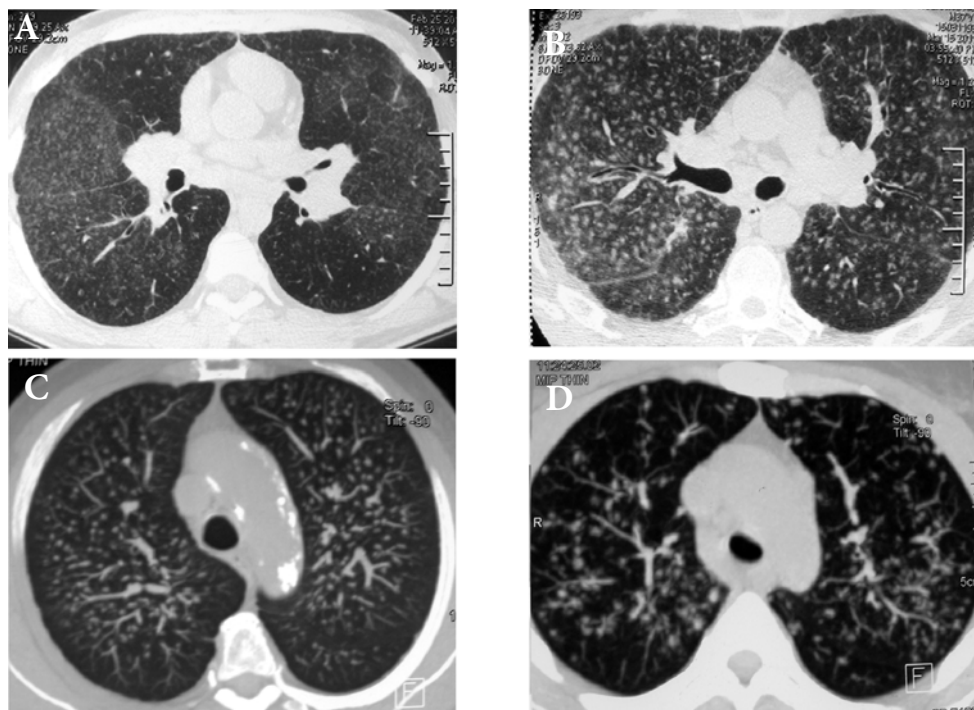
HRCT appearance of pulmonary sarcoidosis. Nodules are the hallmark of sarcoidosis. They are typically distributed in a perilymphatic manner. HRCT can show a large variety of these nodules: from very fine, poorly defined nodules (A, B), accompanied by diffuse ground glass attenuation (A, B), to septal reticulation (arrows, B) and bilateral hilar adenopathy (A, B), to larger nodules with ill defined margins (C, D).
